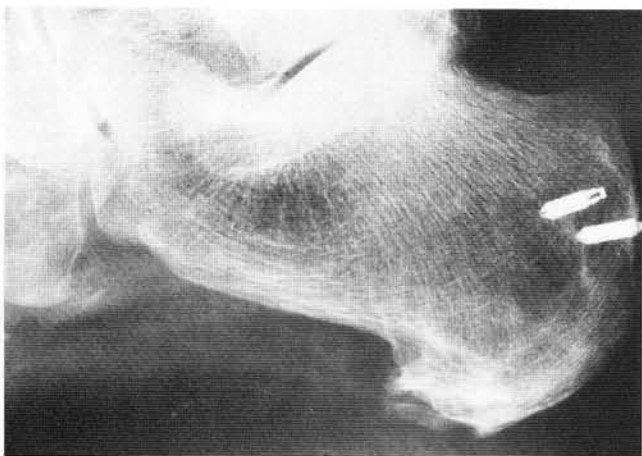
Postoperative radiographic appearance demonstrates adequate resection of retrocalcaneal exostosis and spur with good position of bone anchors.
